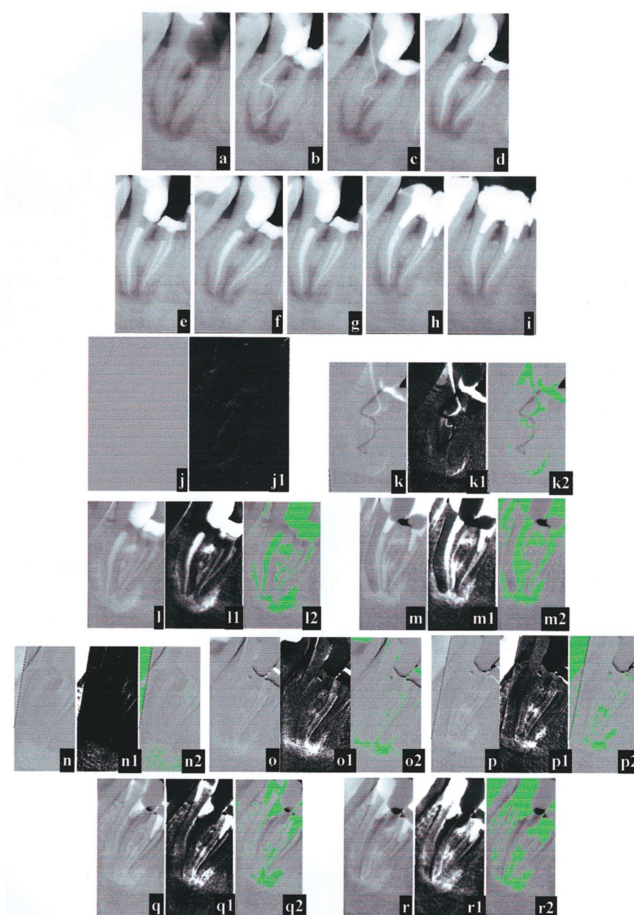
(a) Preoperative radiograph of another first mandibular molar (46) with an intraoral sinus tract. (b, c) Control radiographs after 0.5 and 1 month, respectively. (d) Postoperative radiograph 1.5 months later. (e, f, g, h, i) Recall radiographs 0.5, 1.5, 3, 6, and 12 months after the obturation, respectively. (j) Result of digital subtraction of (a) from itself. (j1) Image (j) processed using contrast enhancement. (k) Result of digital subtraction of (c) from (b). (k1) Image (k) with contrast enhancement. (k2) Pseudocolored image (k). (l) Result of digital subtraction of (f) from (a). (l1) Image (l) processed using contrast enhancement. (l2) Pseudocolored image (l). (m) Result of digital subtraction of (i) from (a). (m1) Image (m) with contrast enhancement. (m2) Image (m) processed using pseudocoloring. (n) Result of digital subtraction of (e) from (d). (n1) Image (n) processed using contrast enhancement. (n2) Pseudocolored image (n). (o) Result of digital subtraction of (f) from (d). (o1) Image (o) with contrast enhancement. (o2) Image (o) processed using pseudocoloring. (p) Result of digital subtraction of (g) from (d). (p1) Image (p) processed using contrast enhancement. (p2) Pseudocolored image (p). (q) Result of digital subtraction of (h) from (d). (q1) Image (q) with contrast enhancement. (q2) Image (q) processed using pseudocoloring. (r) Result of digital subtraction of (i) from (d). (r1) Image (r) processed using contrast enhancement. (r2) Pseudocolored image (r).
